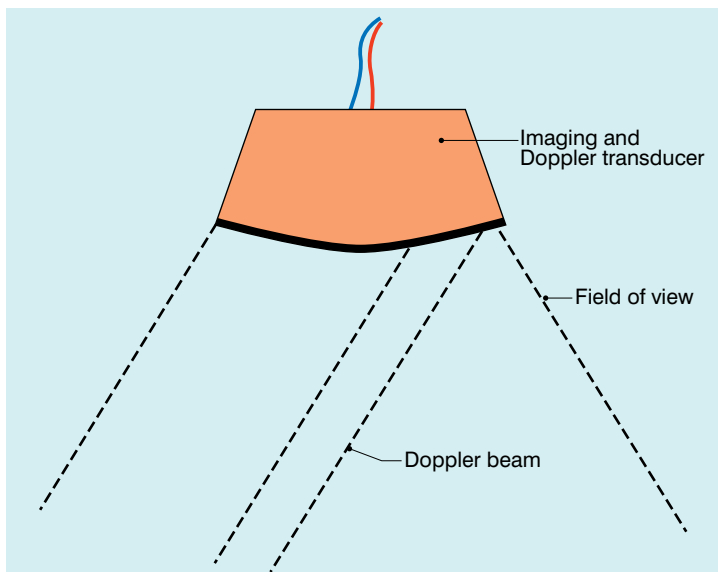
Duplex system combining real-time B-mode and a Doppler beam of variable position across the B-mode field of view.
